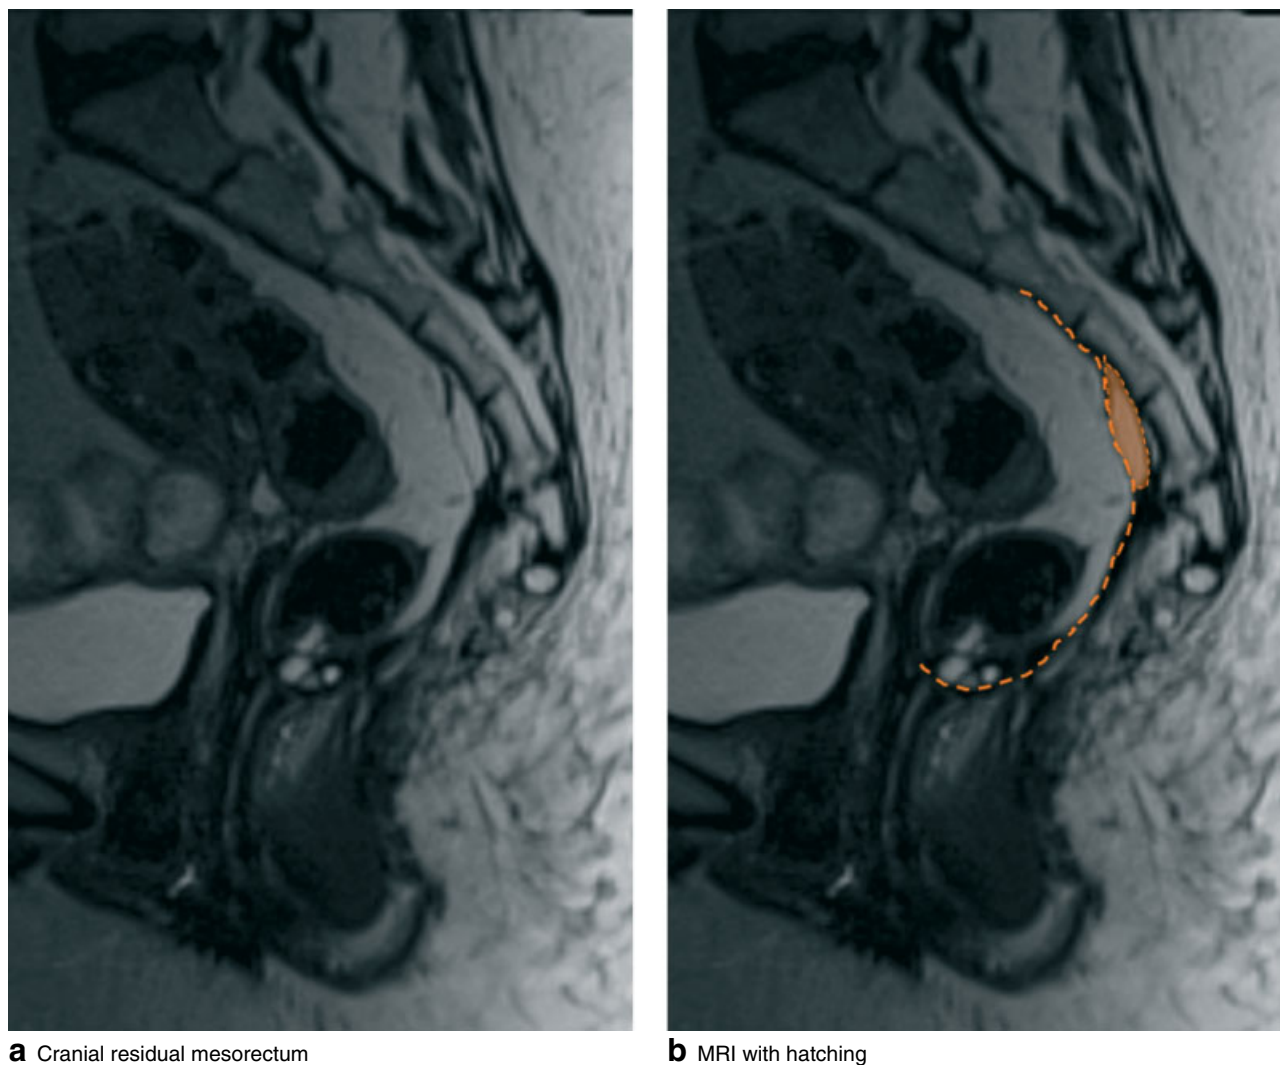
Residual mesorectum after total mesorectal excision. a,b Sagittal T2-weighted images show cranial residual mesorectum (hatched with orange in b). Inclusion cysts are seen in relation to the anastomosis. MRI, magnetic resonance imaging
